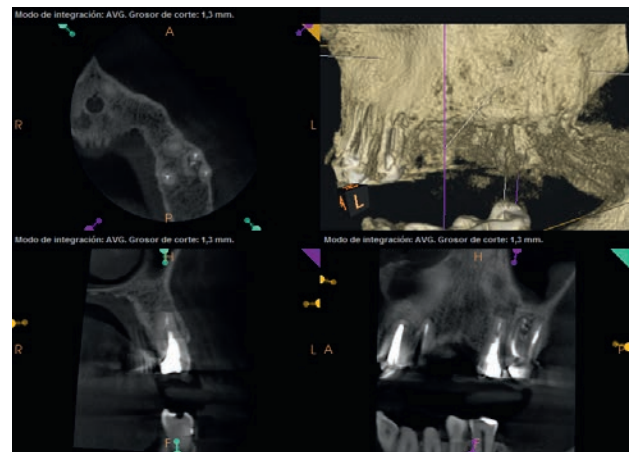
12 months control CBCT image after upper left second premolar after periapical microsurgery, which shows healing of the previous periapical radiolucent lesion.
